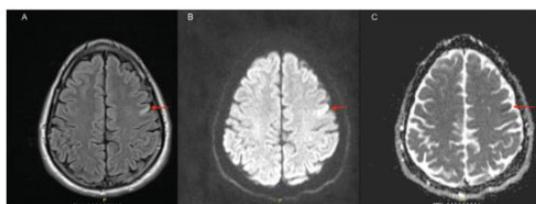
Migrainous infraction in a patient with migraine with aura. A: Axial fluid-attenuated inversion recovery image (FLAIR) sequence showing hyperintense signal in the left frontoparietal cortex. B: Diffusion-weighted image (DWI) sequence showing high signal intensity in the same region. C: Corresponding low value on apparent diffusion coefficient mapping (ADC)
